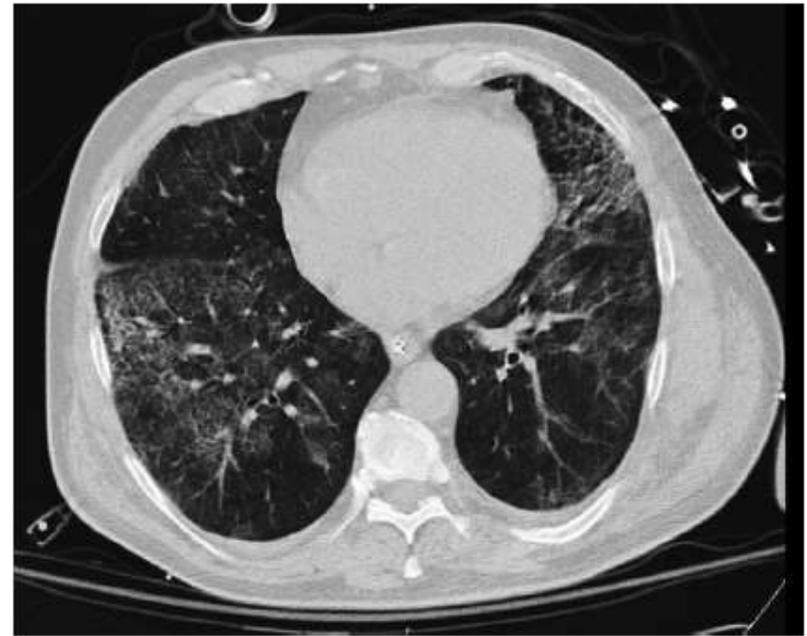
The same patient as in Figure 33.3, 48 hours after a recruitment maneuver (opening pressure 65 cm H₂O) and a decremental PEEP trial. The PEEP was 16 cm H₂O at the time of the CT.
